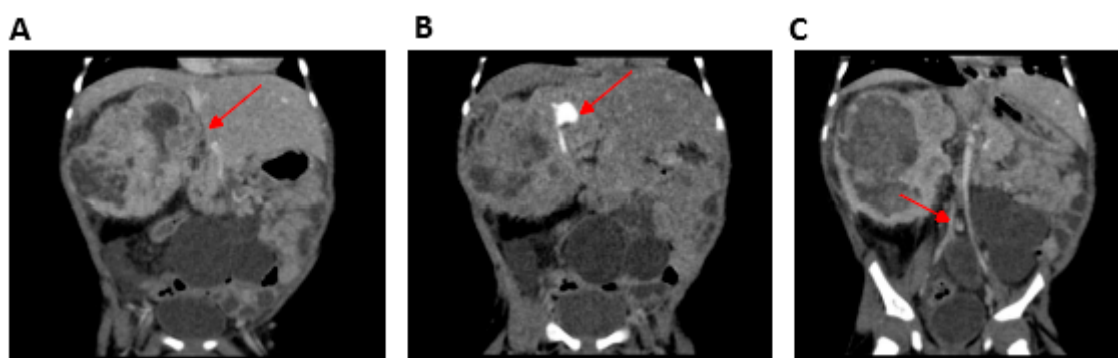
Computerized tomography (CT) urogram of Patient 2 (P2) (performed after vincristine therapy and before surgery). (A) Mesoblastic nephroma located in the right kidney (arrow), (B) contrast-enhanced portion of the functioning right kidney located in the superior pole of the nephroma (arrow) without a cleavage plane, and (C) multicystic left kidney (arrow).
